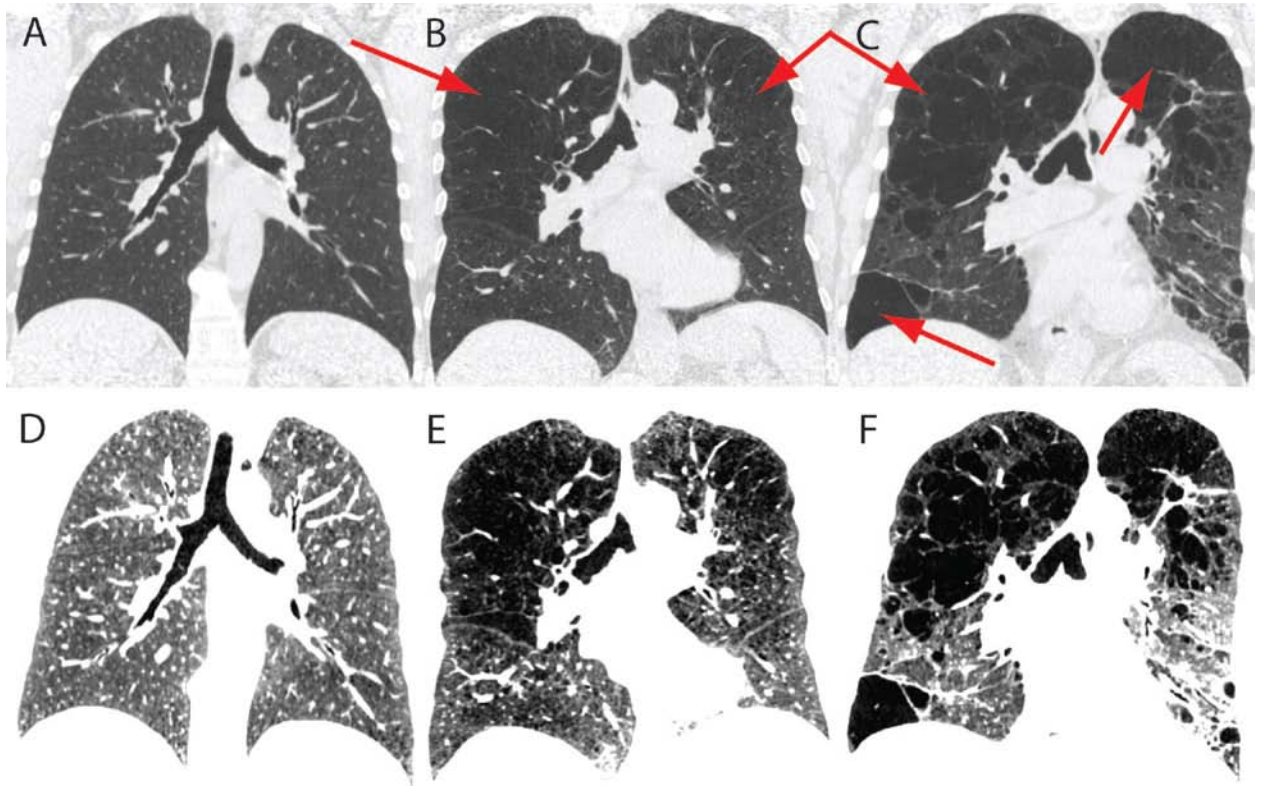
X-ray CT of healthy and emphysematous lungs
